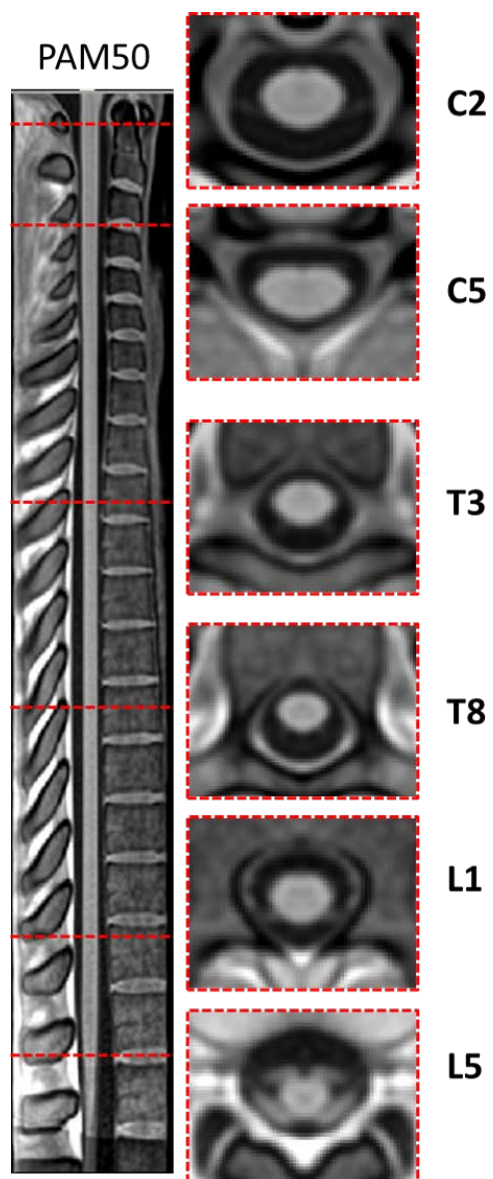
Cross section of the spinal cord in the PAM50 T1w MRI template for various spinal levels.
